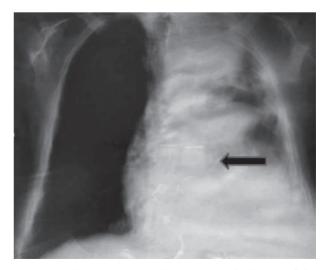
Chest X-ray - non-homogenous shadowing of the left lung.
